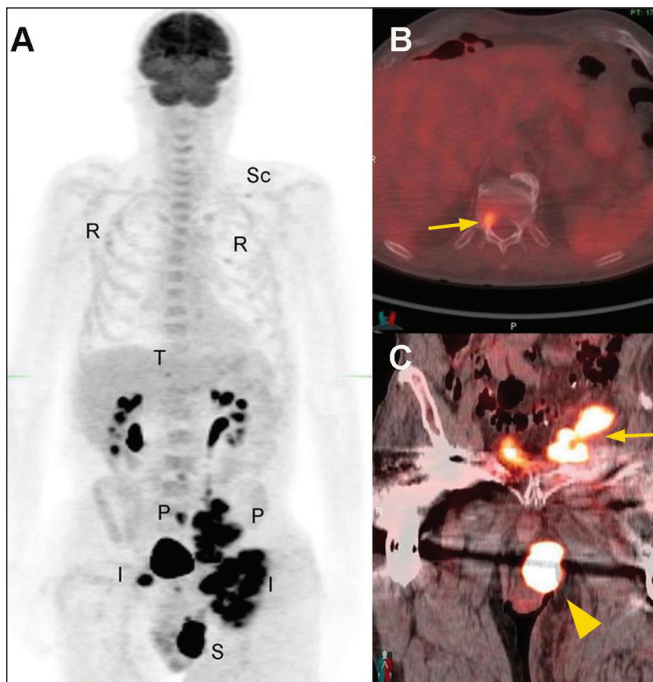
Maximum-intensity projection ¹⁸F-FDG PET/CT (A) showing the left scrotal lesion (S), bilateral inguinal adenopathy (I), and pelvic adenopathy (P), as well as osseous metastases involving the T12 vertebra (T), multiple ribs (R), and the left scapula (Sc). Fused axial and coronal ¹⁸F-FDG PET/CT images showing the T12 vertebra metastasis (arrow in B), together with the left scrotal lesion and left pelvic lymph node metastasis (arrowhead and arrow, respectively, in C).
